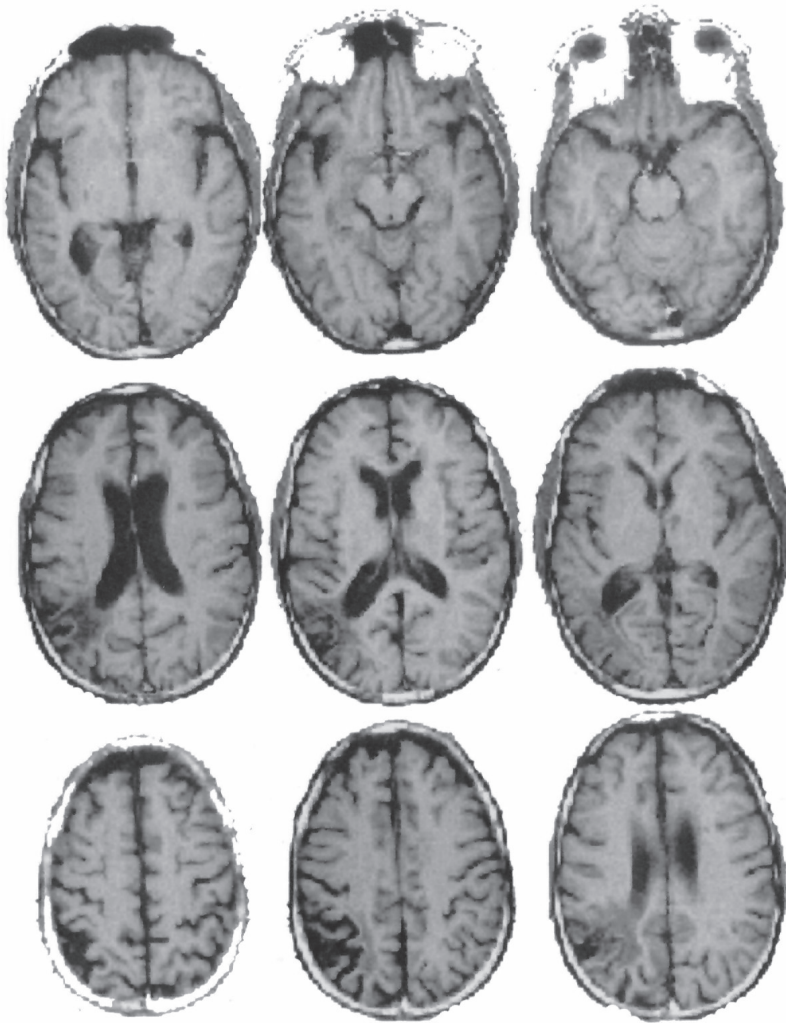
Axial T1 weighted MRI of the brain shows generalized atrophy with involvement of cortical and subcortical white matter. A chronic infarct in the left parietaloccipital junction and lacunar right thalamic infarct is seen.
